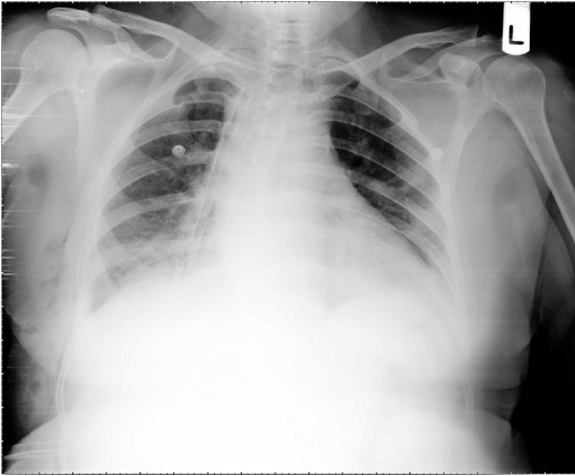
Radiographic image of the adult BH after operation, complete expansion of the right lung.
